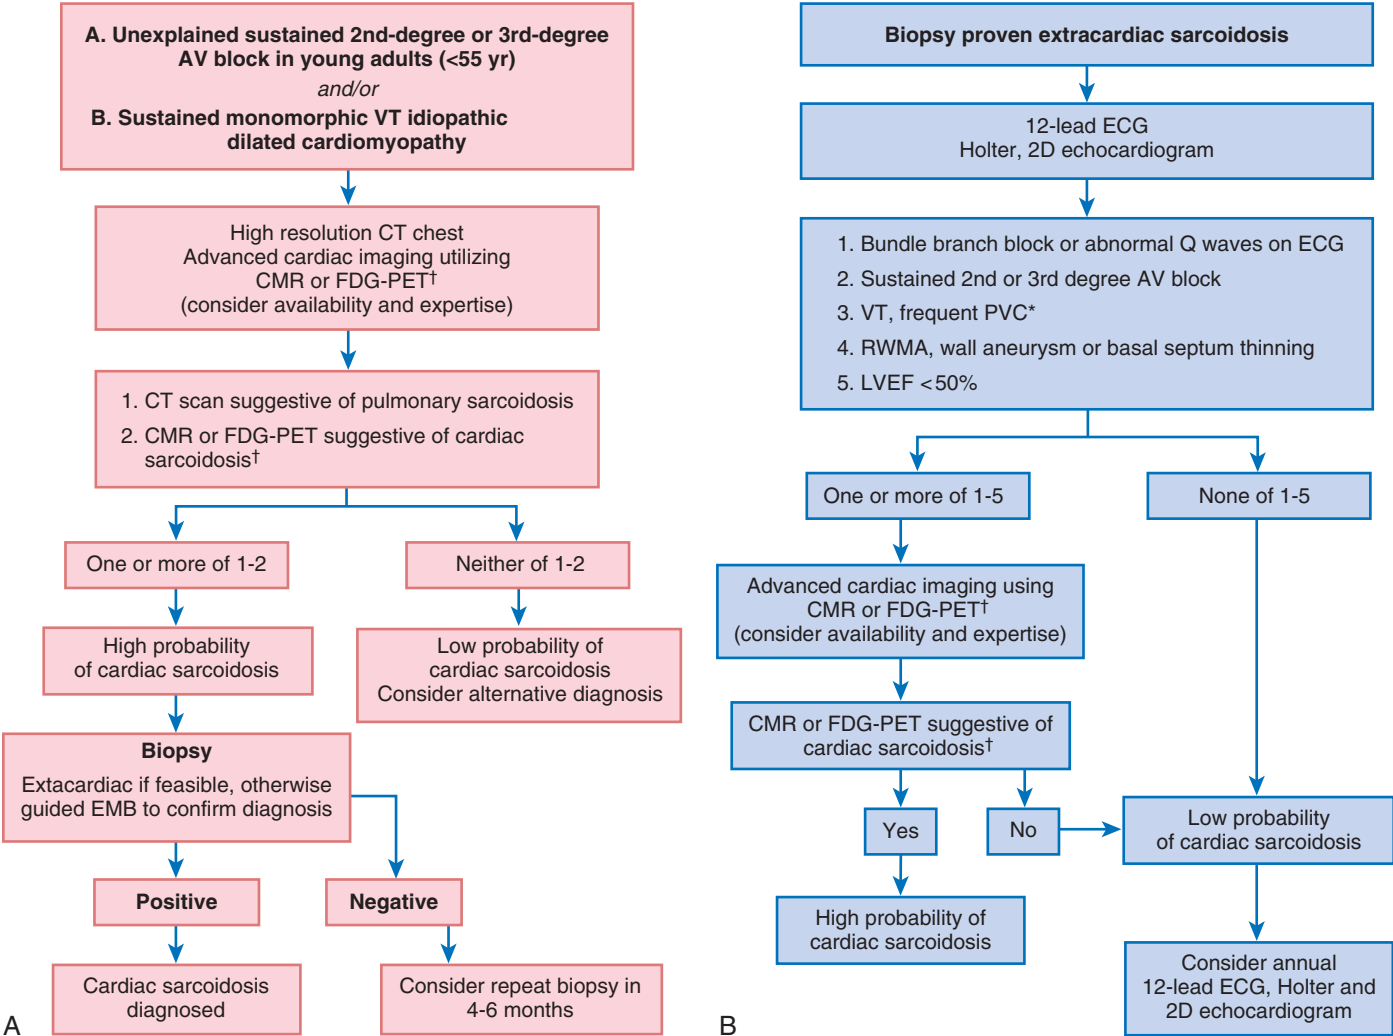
FIGURE e65-6 Diagnostic algorithm for cardiac sarcoidosis. The diagnostic approach differs according to the clinical findings, including conduction system disease and/or ventricular arrhythmia (A) or biopsy-proven extracardiac sarcoidosis (B). *In the absence of coronary artery disease, defined as more than 1000 PVCs per 24 hours. [†]Gallium-67 scintigraphy or technetium-based myocardial perfusion imaging are reasonable alternatives if FDG-PET or CMR is not available. CMR = cardiac magnetic resonance; EMB = endomyocardial biopsy; LVEF = LV ejection fraction; RWMA = regional wall motion abnormality. (From Youssef G, Beanlands RS, Birnie DH, Nery PB: Cardiac sarcoidosis: Applications of imaging in diagnosis and directing treatment. *Heart* 97:2078, 2011.)
